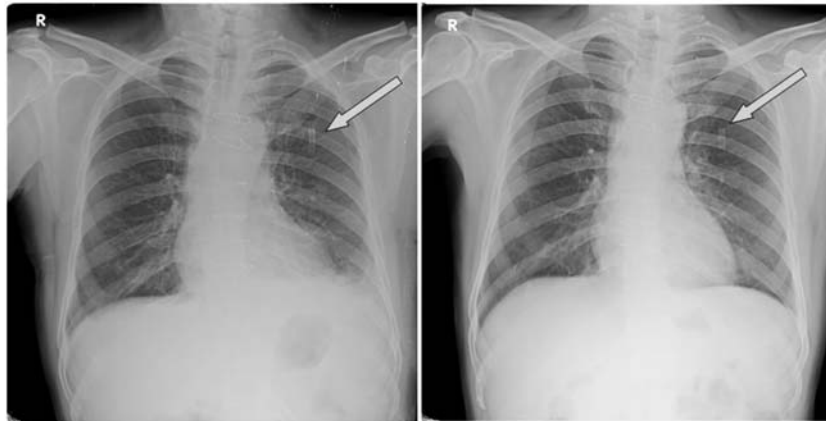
The appearance of a foreign body (arrow) on 2 separate chest radiographs.
